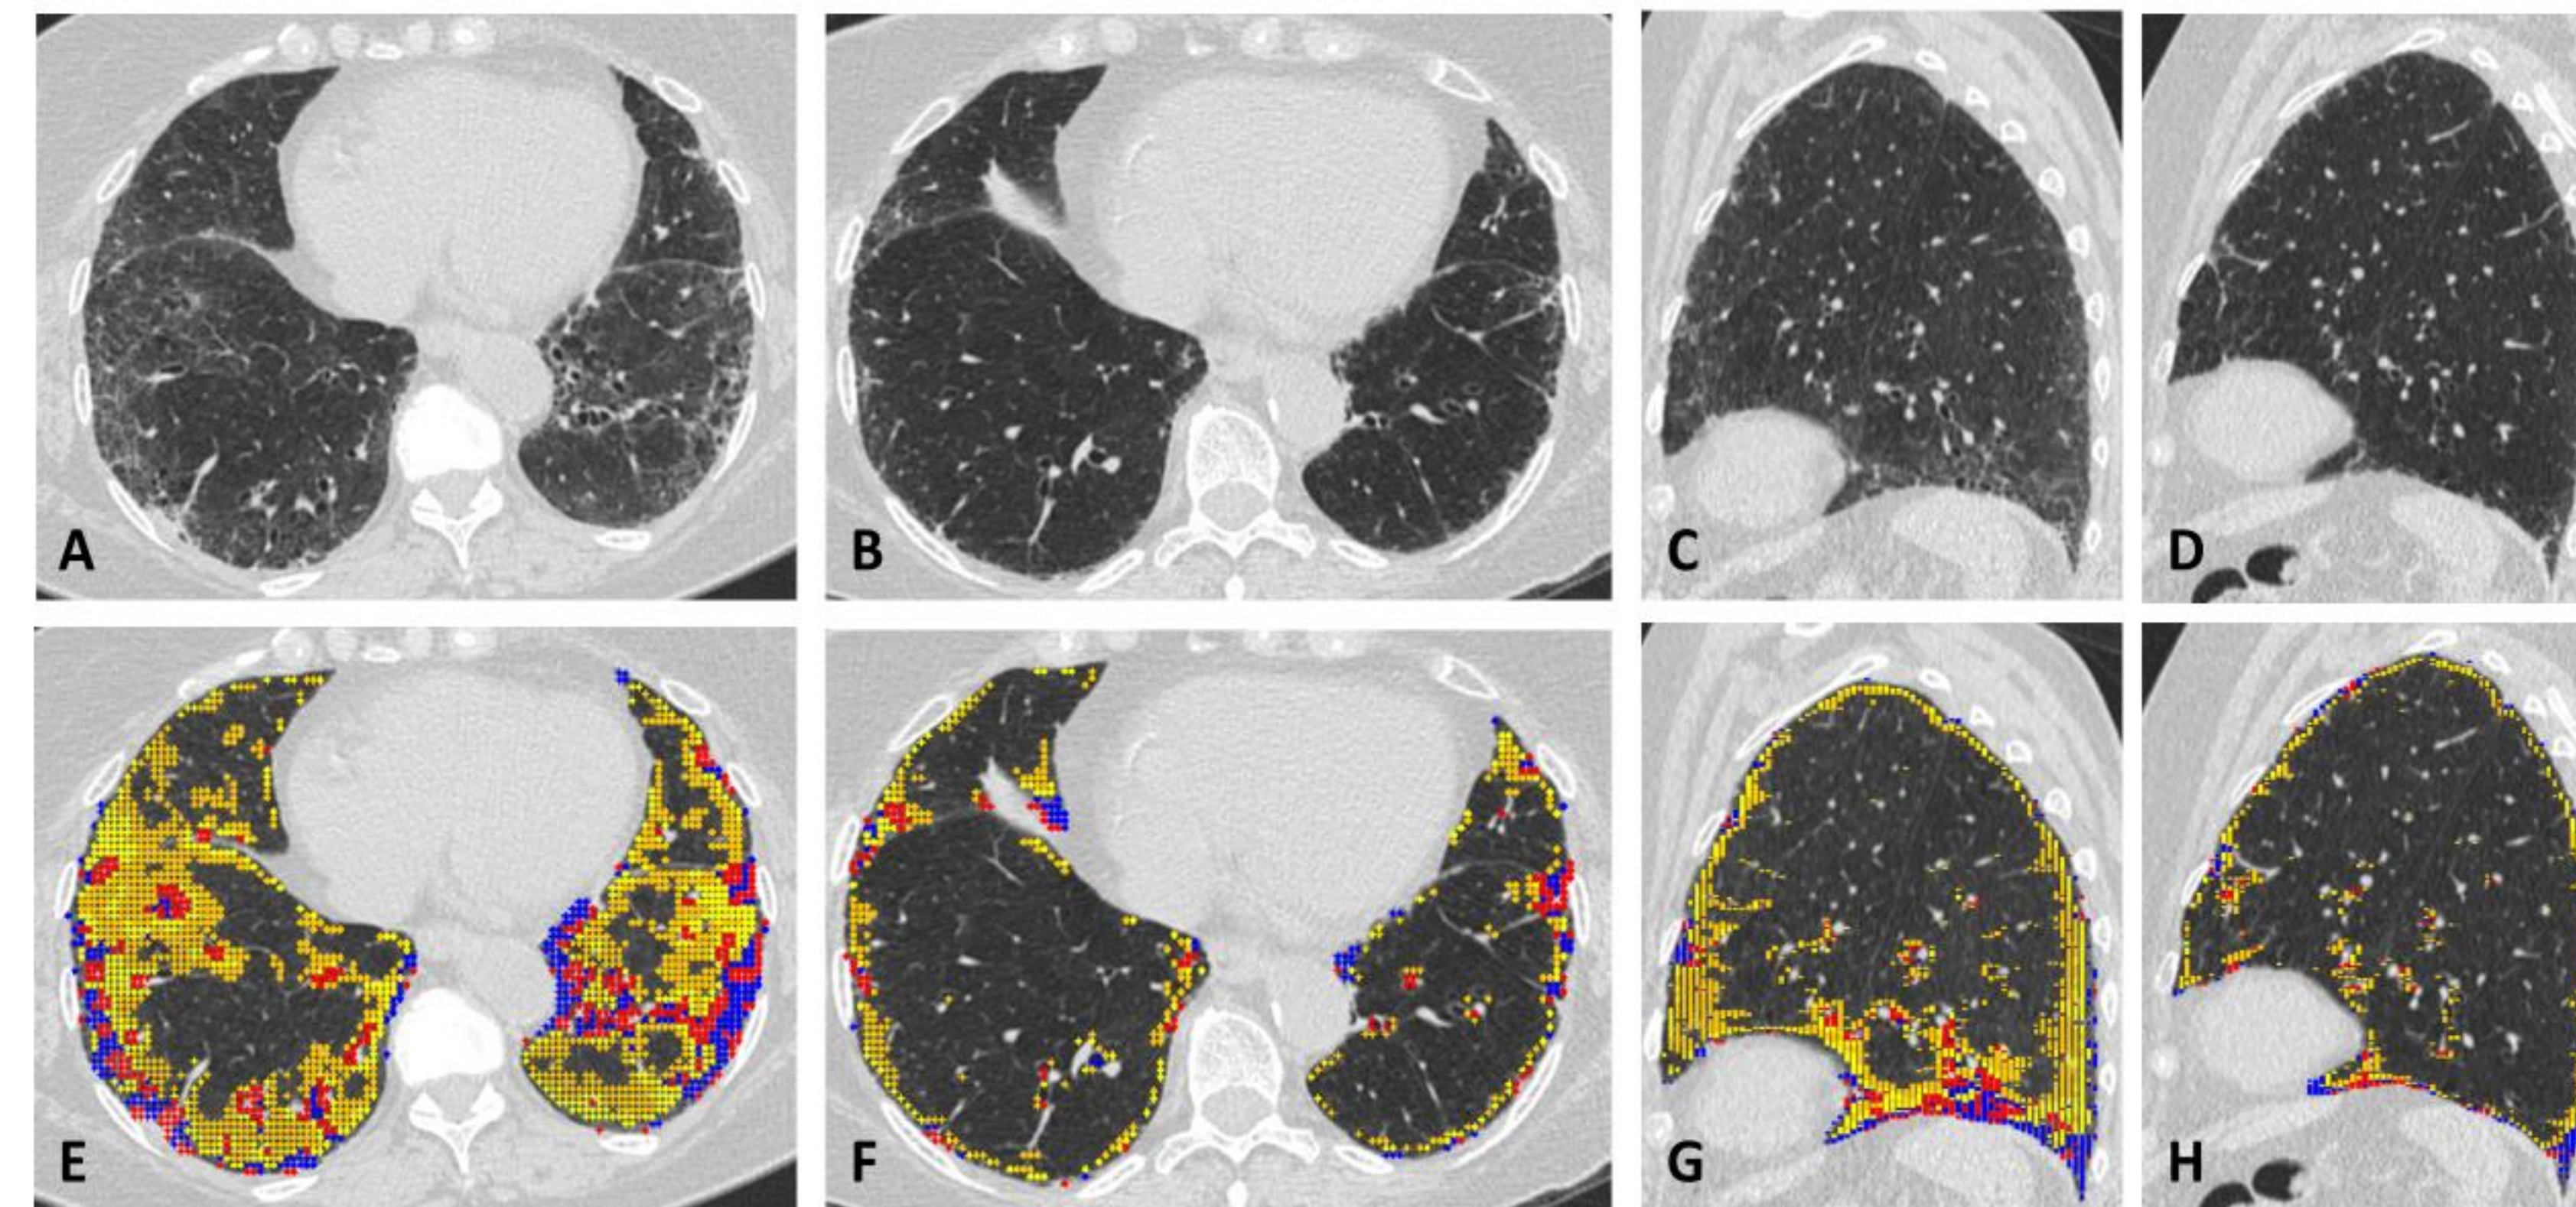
A, B, C, and D: axial and sagittal HRCT images; E, F, G, and H: overlaid quantitative results of the corresponding images of A, B, C, and D. Blue and red dots indicate the results of QLF classification; yellow dots indicate the ground glass. A and C: from the baseline CT. B and D: from the 6-month follow-up CT scans. QLF score in whole lung was 8.5% at baseline and 4.9% at 6-month follow-up. QLF volume in whole lung was 258.2 mL at baseline and 154.2 mL at 6-month follow-up. The QLF in the left lower lobe, especially, was reduced from 23.7% (90.6 mL) to 10.6% (45.2 mL).
